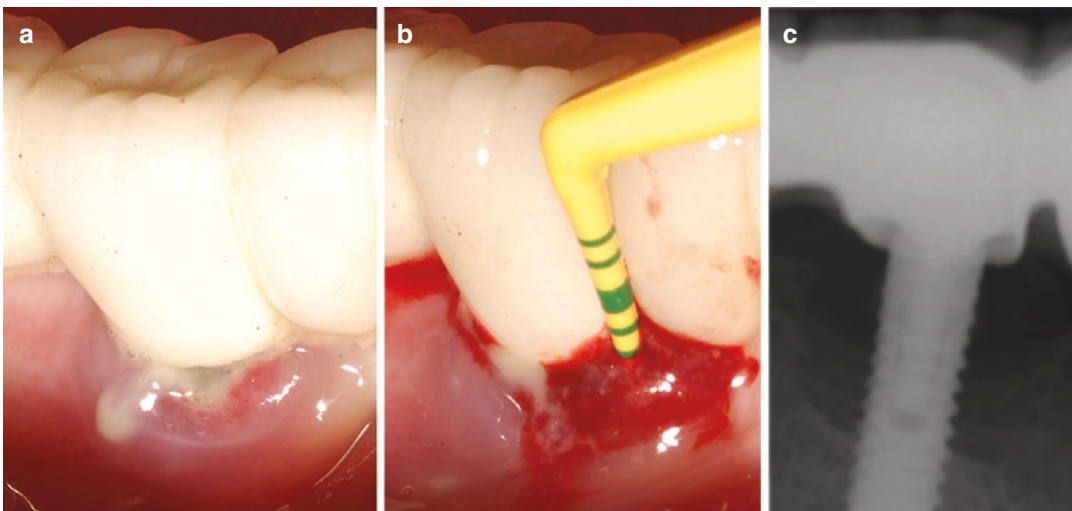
Clinical and radiographic findings of a peri-implantitis case. (a) Presence of visual inflammatory changes around the peri-implant soft tissue evident by redness, swelling, ulceration, and suppuration. (b)
